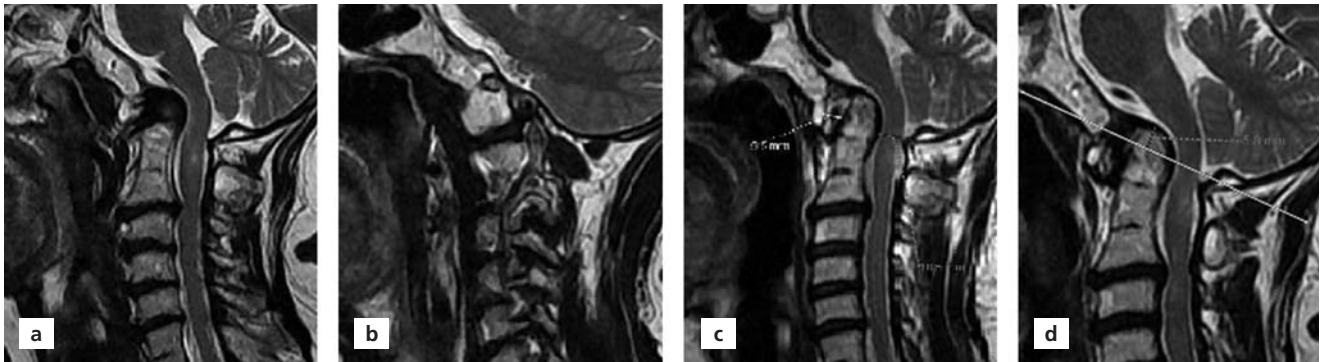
(a, b) A 58-year-old female presented with chronic head and neck pain. At sagittal T2-weighted images, complete form AOA is seen as fusion of anterior arch, posterior arch and lateral masses of C2 vertebra. Spinal cord myelomalacia at the C2 level and fusion of C2 and C3 vertebra also accompanied. (c) AADI increased to 5.5 mm whereas PADI decreased to 10.5 mm, revealing craniocervical instability. (d) The tip of odontoid process was projecting more than 3 mm (5.8 mm) above the Chamberline's line, compatible with basilar invagination.
